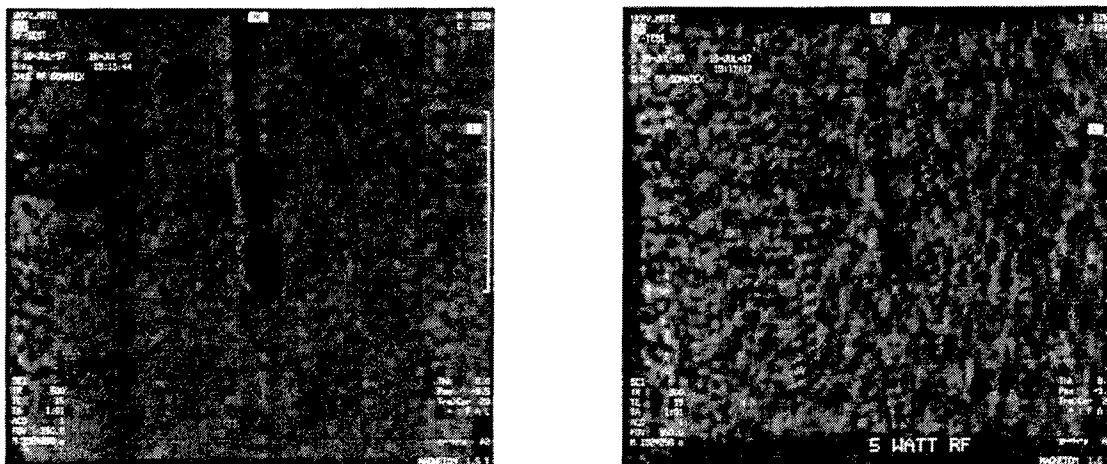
MRI monitoring tests of a bipolar RF-applicator without (left) and with RF-current flow (right)
